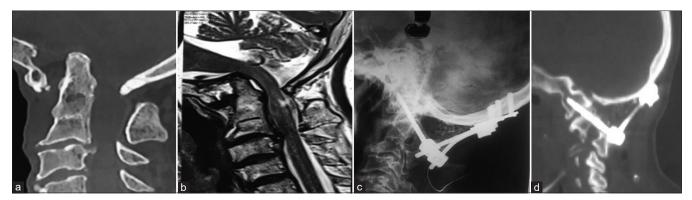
(a) Showing computed tomography scan of a patient with occipitocervical instability. (b) Showing magnetic resonance imaging with cord compression. (c) Indicating postoperative lateral X-ray after occipitocervical fusion. (d) Showing postoperative computed tomography scan with occipitocervical fusion
